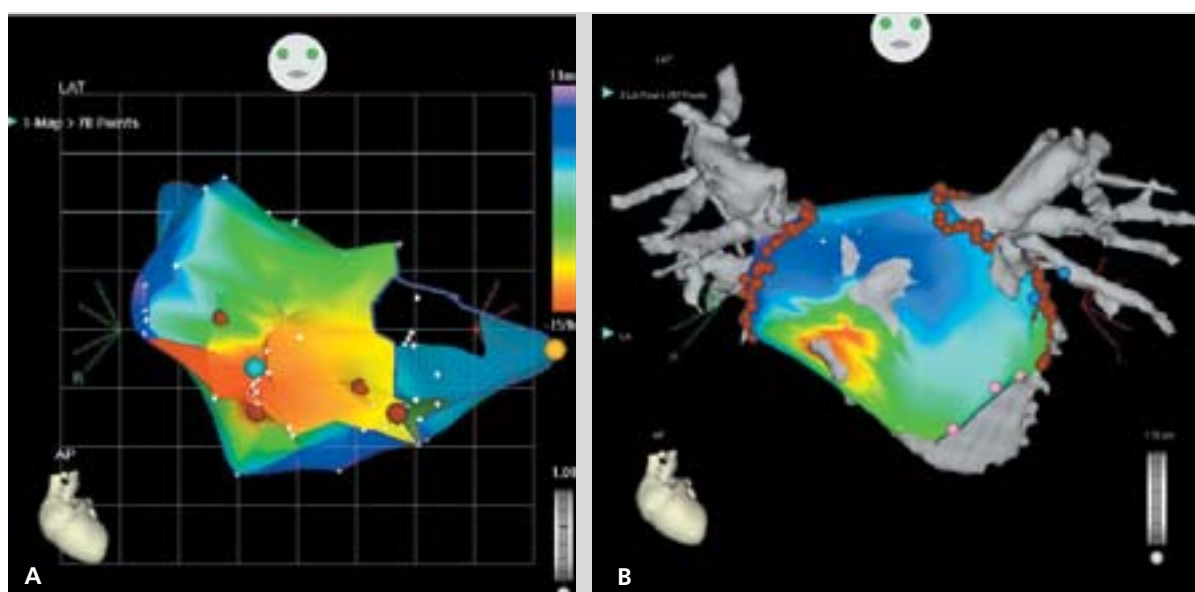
A. Example of an electro-anatomical reconstruction of the right atrium in a patient with focal right atrial fibrillation. B. The 3-D fusion of an electro-anatomical map of the left atrium with the pre-interventionally acquired 3-D CT data offers the opportunity to increase orientation, safety and efficacy in ablation therapy and to reduce fluoroscopy time and radiation exposure.
